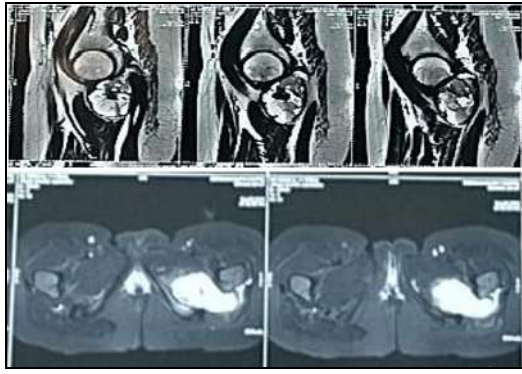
MRI suggestive of a well defined lesion with multiple differential intensity fluid levels along the posterior aspect of neck of left femur with extension into myofascial plane in left hamstring muscles? Haematoma/ Detached Aneurysmal bone cyst.
